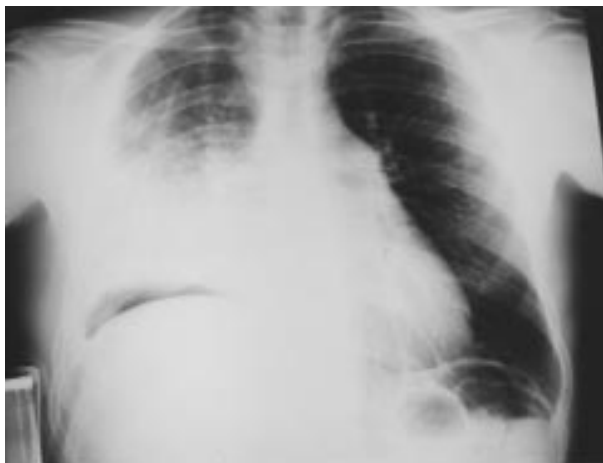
Chest radiograph obtained on the first postoperative day showing an infiltrate in the lower half of the right upper lobe.
